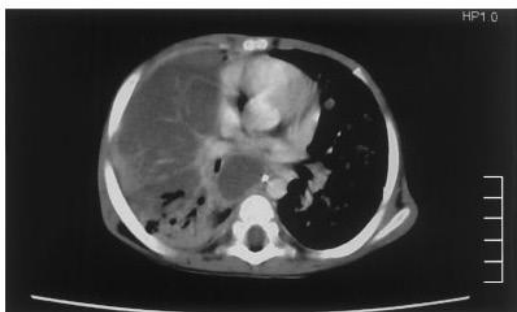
Computed tomography showing massive enlarged subcarinal lymphadenopathy and densely opacified right upper lobe, with liquefaction in both glands and lung tissue. Compression of airways is also visible.
